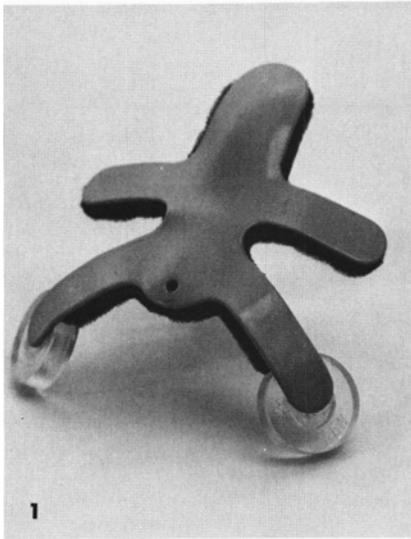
Thumbsplint with Co-57 point source markers attached. FIG. 2. Setting width of the Co-57 markers: (A) Flood image measures 7.2 cm across. (B) Distance between centers of Co-57 markers adjusted to 7.2 cm. FIG. 3. (A) Thumbsplint in situ. (B) Cross-sectional representation of splint showing Co-57 markers and thyroid gland in same plane, essential for undistorted measurement. FIG. 4. Normal thyroid scan. FIG. 5. Graves' disease thyroid scan. FIG. 6. Dominant cold cystic nodule in a multinodular gland measuring 2.5 cm in length by (A) pinhole Anger camera scanning and (B) ultrasound.
